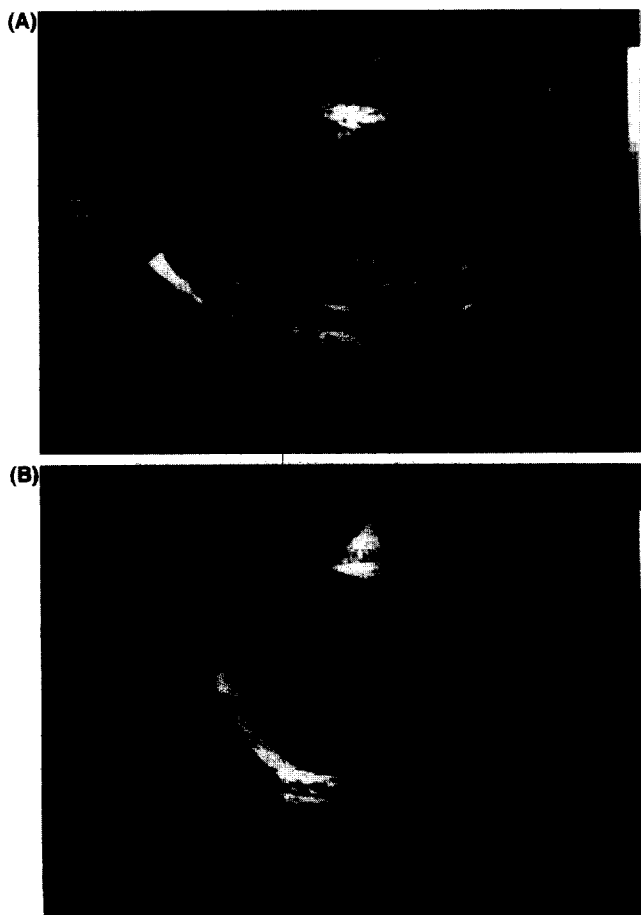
(A) Preoperative echocardiographic examination: long axis view. The arrow shows the accessory mitral valve leaflet. (B) Postoperative examination: long axis view. Normal left ventricular outflow tract can be seen. LV, left ventricle; RV, right ventricle; Ao, aorta.
